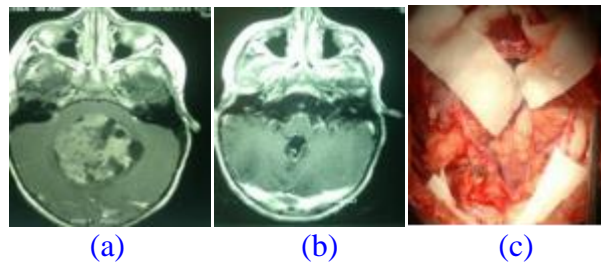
Medulloblastomas FCP MRI Pre (a) and post(b) operative, Image per Operatories (c)
